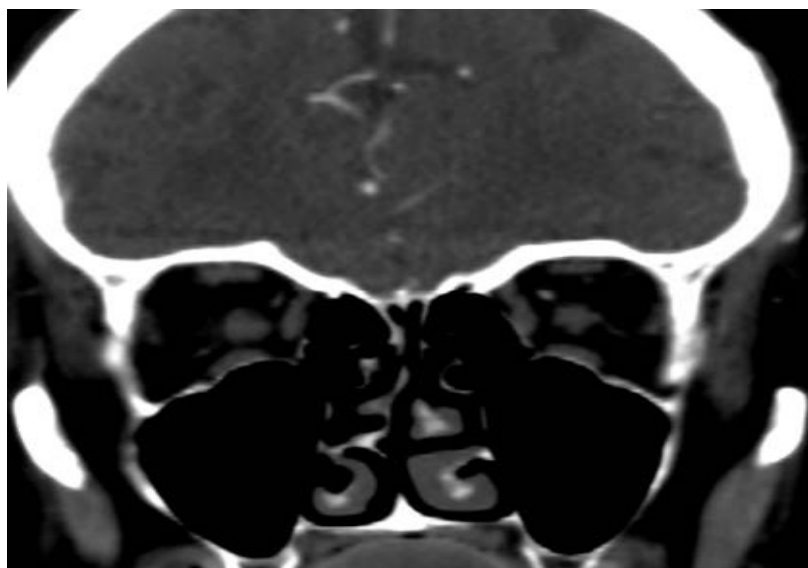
The coronal reformatted image of the Computed Tomography angiography of a central retinal artery occlusion patient.
